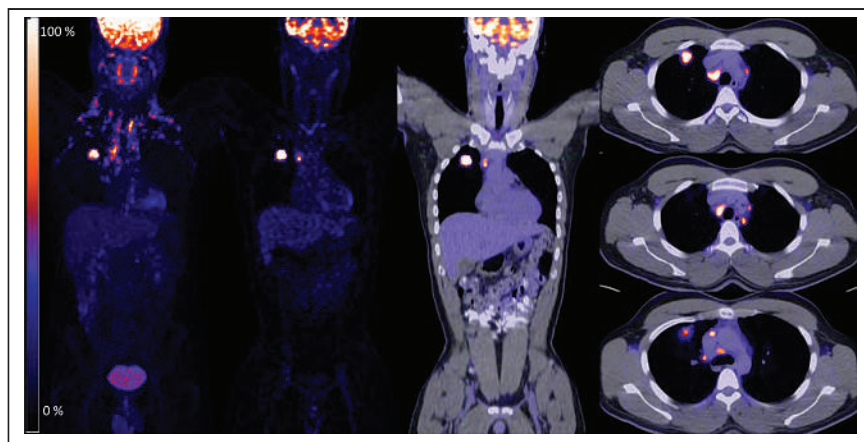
^{18}F -FDG PET/CT scan. Initial staging showing intensely ^{18}F -FDG-avid right-upper-lobe mass with additional ^{18}F -FDG-avid mediastinal lymph nodes. From right to left maximum-intensity-projection PET, coronal PET, coronal PET/CT, and axial PET/CT images.
